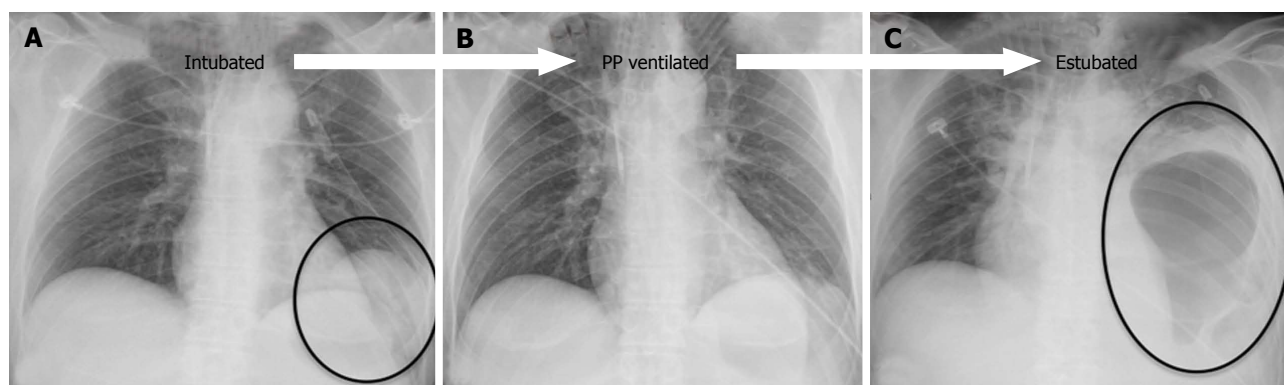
Effects of mechanical ventilation on blunt diaphragmatic lesions. The antero-posterior chest X-ray, performed immediately after intubation and left pneumothorax drainage (A) in a patient admitted to the ED because of severe motorbike accident, showed a double left diaphragmatic profile (circle), suspicious for BDL. The finding was not confirmed at the subsequent CT, performed after the beginning of positive-pressure ventilation, and also the CXR performed 2 d later, after pleural drainage removal (B) did not show any diaphragm alteration. Three days later, after estubation, the patient suffered respiratory insufficiency and left pleural drainage was replaced in the suspicion of relapsing pneumothorax; subsequent CXR (C) clearly demonstrated the presence of BDL with intra-thoracic gastric herniation (circle). BDL: Blunt diaphragmatic lesions; CXR: Chest X-ray; CT: Computed tomography; ED: Emergency Department.
